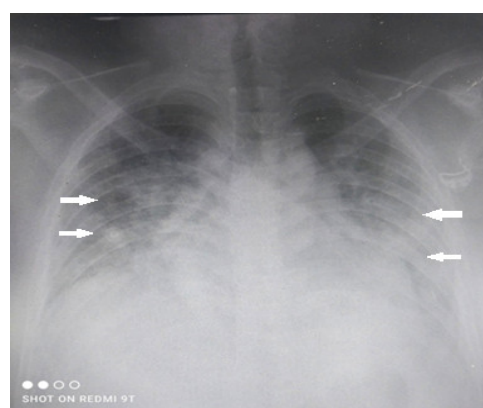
The Chest X-ray the patient at 14th hours of admission showed bilateral difuse pathchy infiltrates
